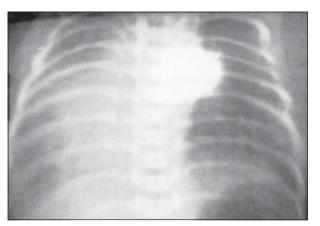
X-ray chest revealing dextrocardia and hypoplastic ribs on the ipsilateral side
